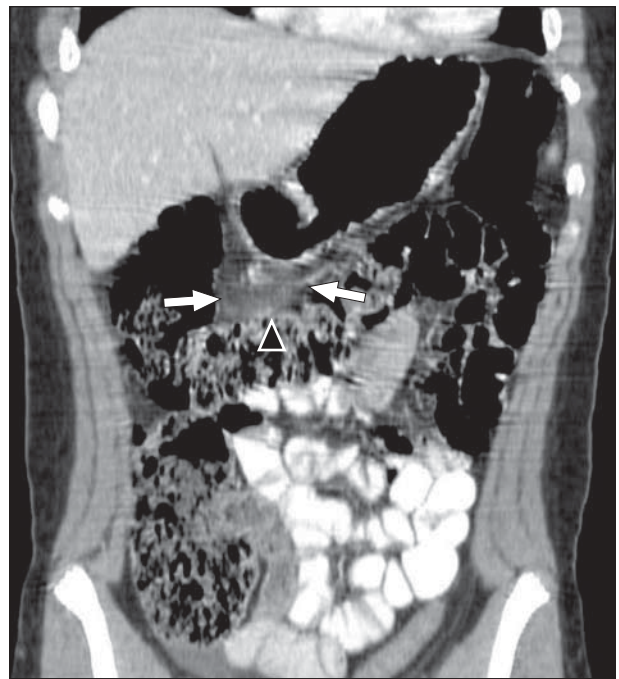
Two-dimensional coronal reconstruction of abdominal computed tomography. Note the position of the triangular hazy gray density (arrows) in relation to the stomach and the transverse colon (arrowhead).
